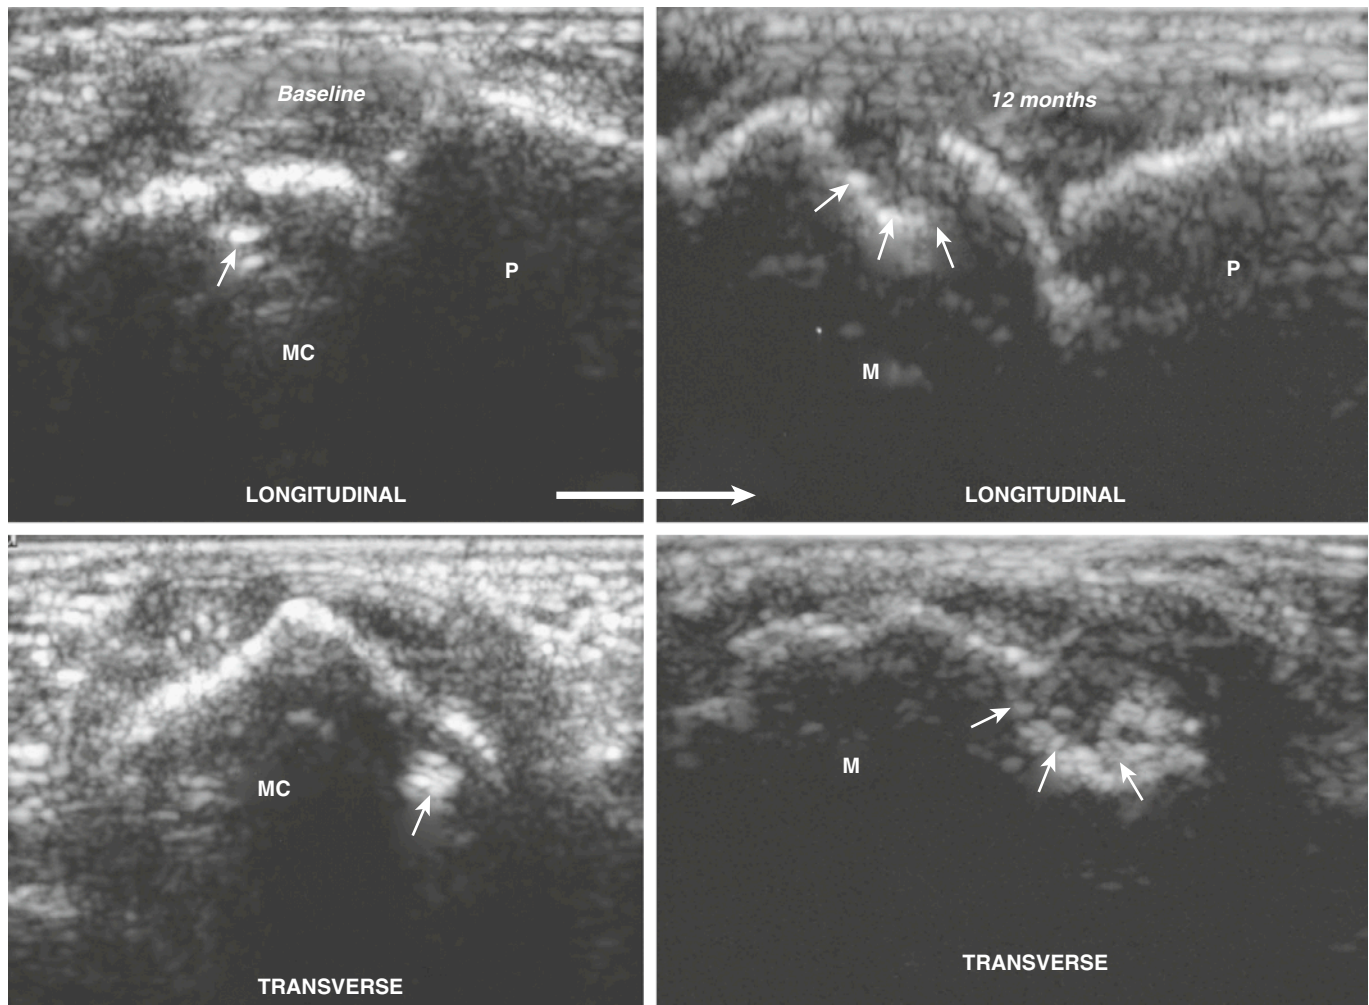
CORTICAL BONE EROSION. Bone erosion progressed over a 12-month period in a patient with rheumatoid arthritis. A small cortical break or erosion (small arrows), which can be seen in the baseline longitudinal and transverse views (left), has rapidly enlarged. The erosion was not seen on the radiograph obtained at baseline, but it was visualized after 12 months. M and MC, metacarpal; P, phalangeal.
